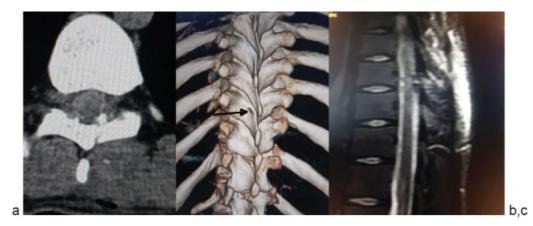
(a) Computed tomography showing fracture of lamina with a small intraspinal fragment underneath. (b) Volume rendering image showing perforation in the lamina (arrow). (c) Sagittal stir MR image showing knife track extending from the skin to the spinal cord and cord contusion.
